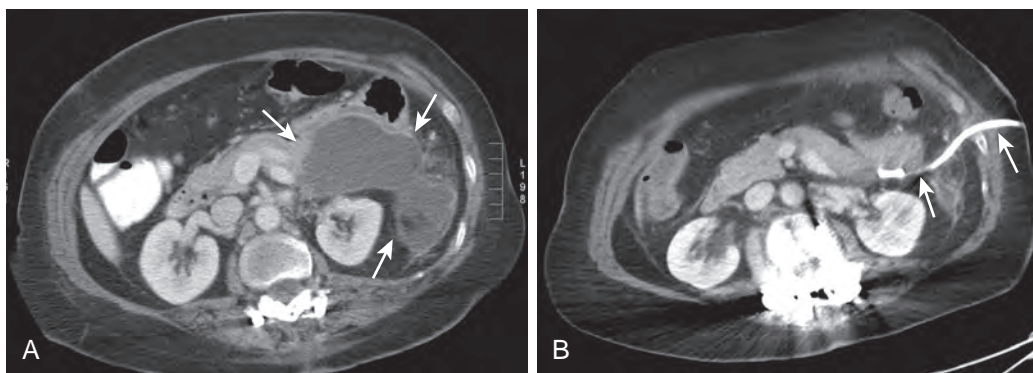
Percutaneous drainage of infected peripancreatic fluid collection. A. Contrast-enhanced axial CT image in a 45-year-old man with acute pancreatitis shows a large fluid collection adjacent to the pancreatic tail (arrows). B. Axial CT image after percutaneous drainage shows resolution of the peripancreatic abscess (arrows).
